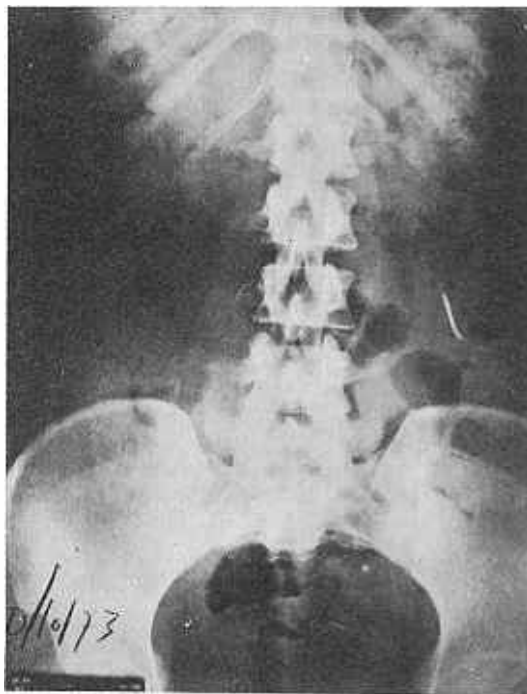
Plain X-ray film of case 2 showing translocated position of Copper-7 IUD high up in left lumbar region.
